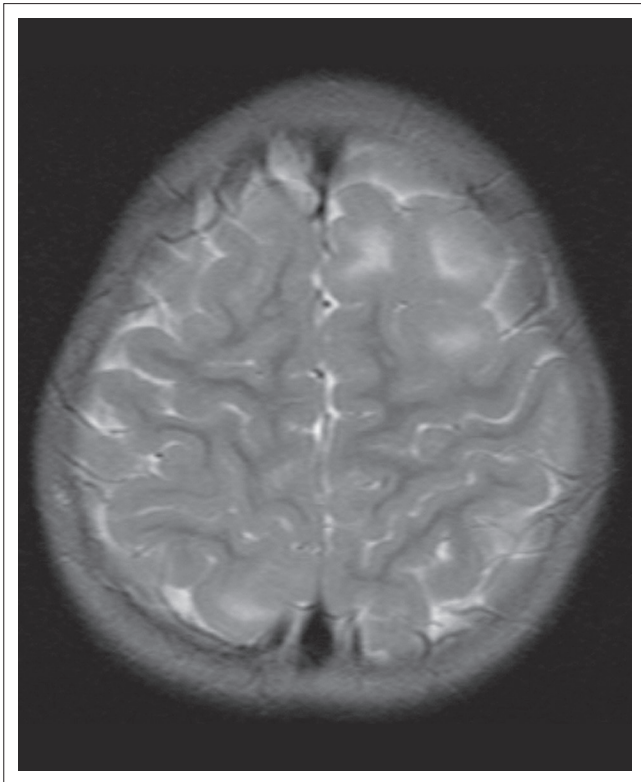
Axial T2-weighted MR image.
